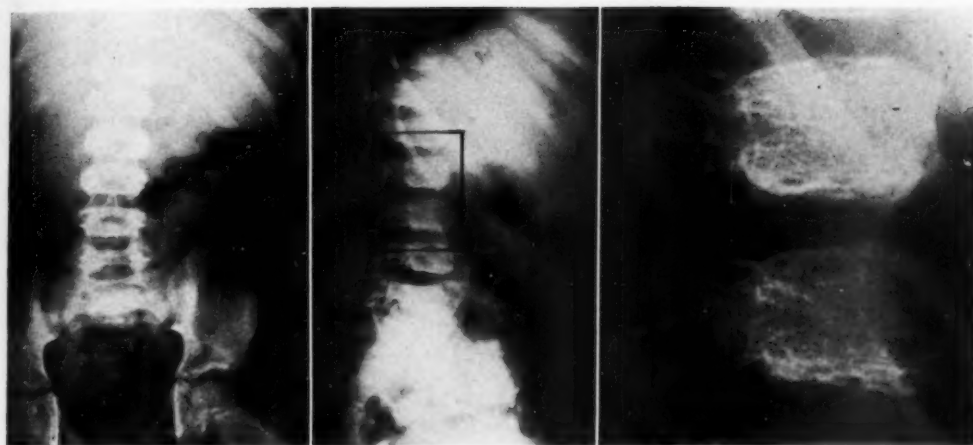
Irregular conversion of cartilage to bone. Films of the lumbar spine ten years after postoperative roentgen therapy for embryonal carcinoma of the testicle in a sixteen-month-old child. The calculated incidental dose to the body of L-2 was 1,245 r in forty-two days and, one month later, 1,455 r in fourteen days.
